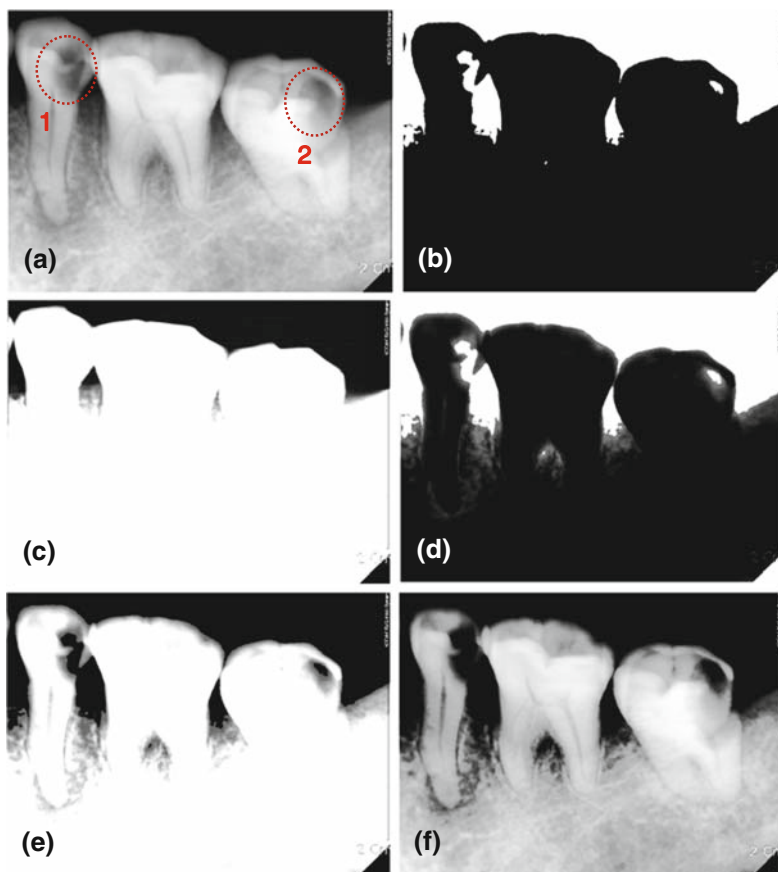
Emphasis image of hidden proximal caries from single dental image of patient by digital subtraction radiography. (a) Original image. (b) Binary image. (c) Triploid original image. (d) Digital subtraction radiography. (e) Reverse image. (f) Emphasis image in hidden dental caries from final digital subtraction radiography
